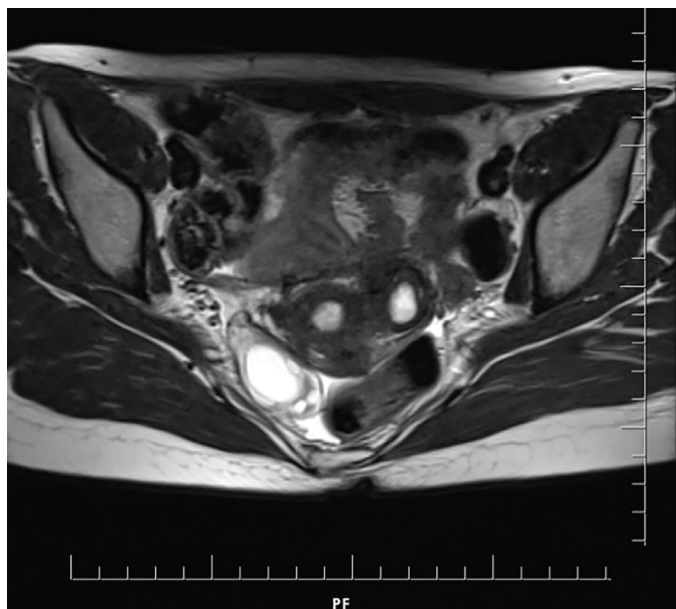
T2-weighted magnetic resonance imaging image of the mass (accessory cavitated uterine mass)
